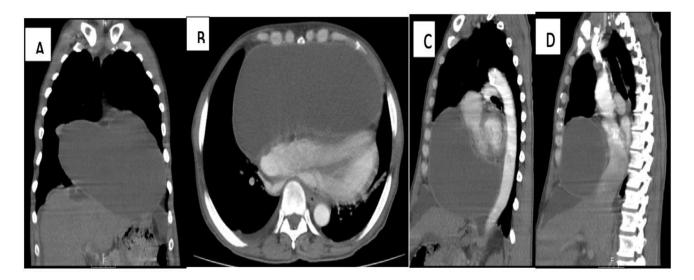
CECT scan of the chest (A) coronal, (B) axial, (C, D) sagittal, showing a large thin-walled nonenhancing homogenous cystic lesion in the anterior and middle mediastinum, right pleural effusion and a dilated inferior vena cava. CECT, contrast-enhanced computed tomography.
